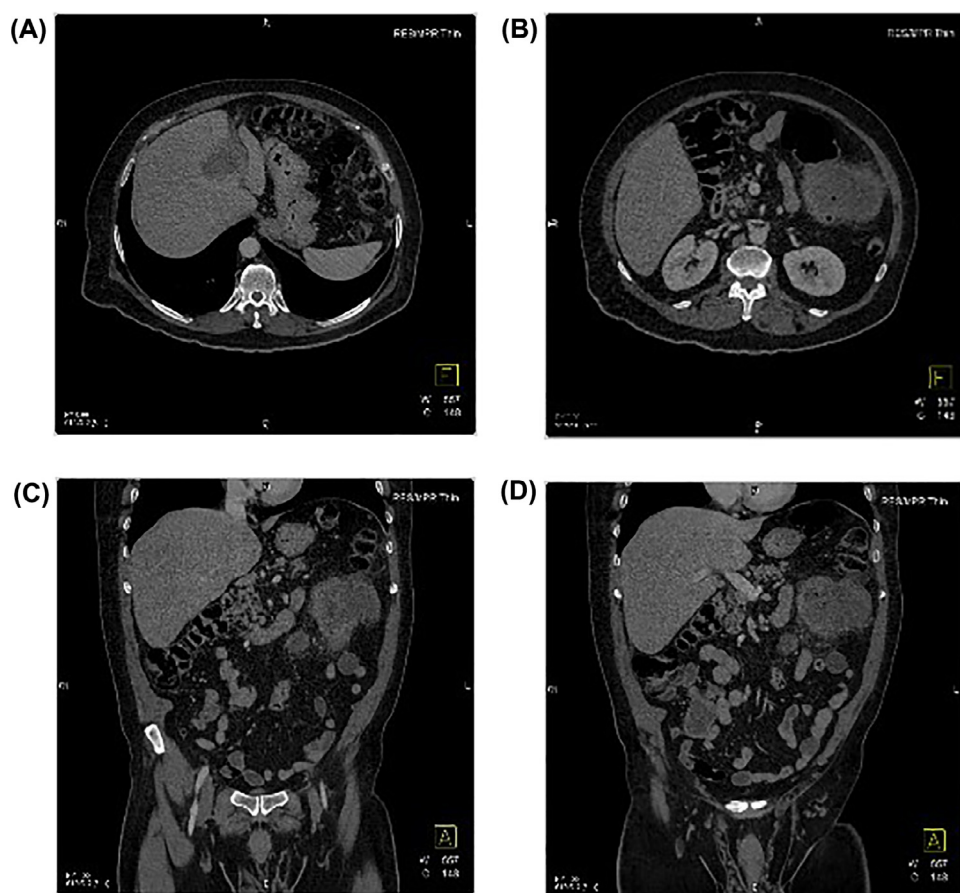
A 68-year-old male with increasing abdominal pain for the previous 10 days. Beyond abdominal distension the physical exam was unremarkable. (A) CT scan through the upper abdomen defines a 3.2 cm cystic hypodense lesion in the liver. (B) A CT scan shows evidence of a 7.7 cm necrotic process near the region of the descending colon. (C and D) Coronal CT scans defined a necrotic mass near the descending colon consistent with an inflammatory process or tumor.
